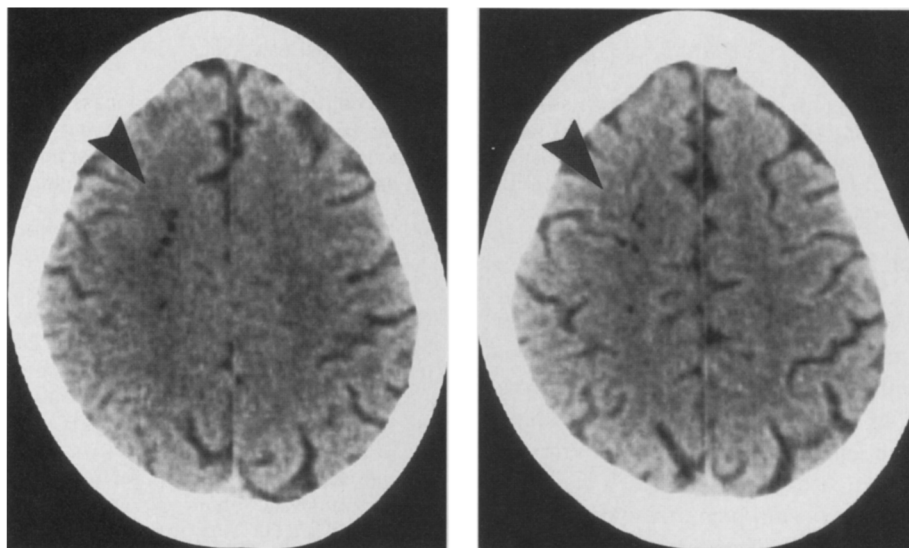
Noncontrast, computed tomography scan of the head. Serial 5-mm axial images at the level of the cerebral convexity show the presence of air deposits (indicated by arrowheads) in the right superior frontal lobe.
